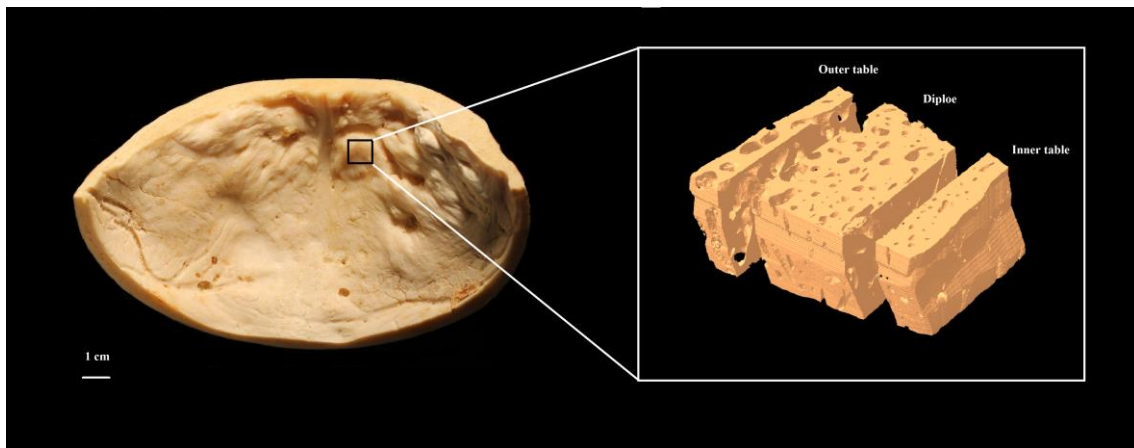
(left panel) A macroscopic view on the internal surface of the frontal bone in a woman with HFI (black rectangle shows the location of the analyzed frontal bone sample). (right panel) A 3D micro-computed tomography reconstruction in a woman with HFI, showing the segmentation of the frontal bone samples to the regions of outer table, diploe and inner table.
